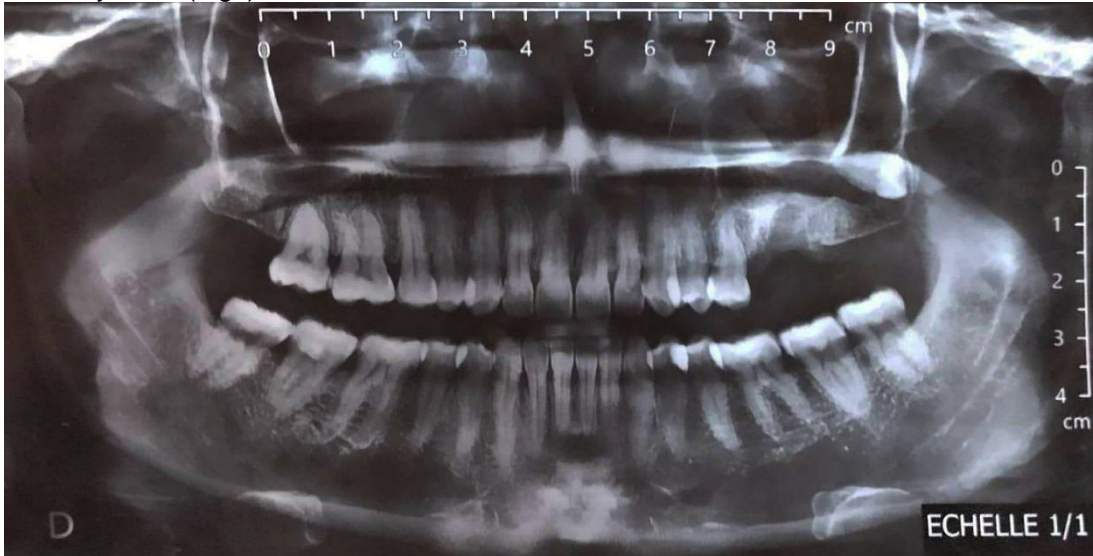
Preoperative panoramic radiograph of an ectopic eruption of the left maxillary third molar into the left maxillary sinus.
